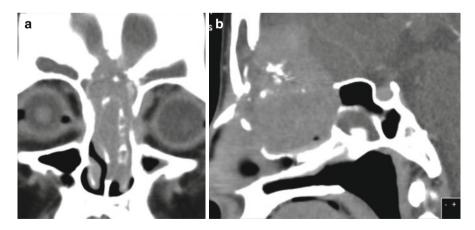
(a) (coronal CT) and (b) (coronal T1-weighted MRI with gadolinium): *Right* sinonasal adenocarcinoma with extension into frontal sinus
